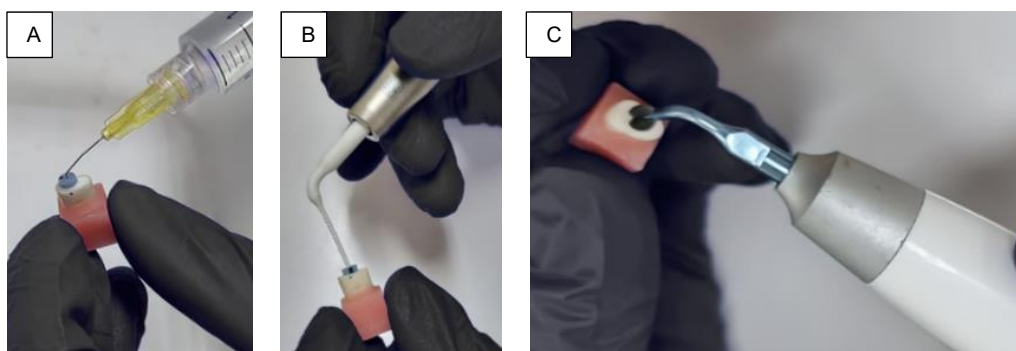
Root canal irrigation. (A) Manual agitation technique, (B) Sonic agitation technique, (C) Ultrasonic agitation technique.
